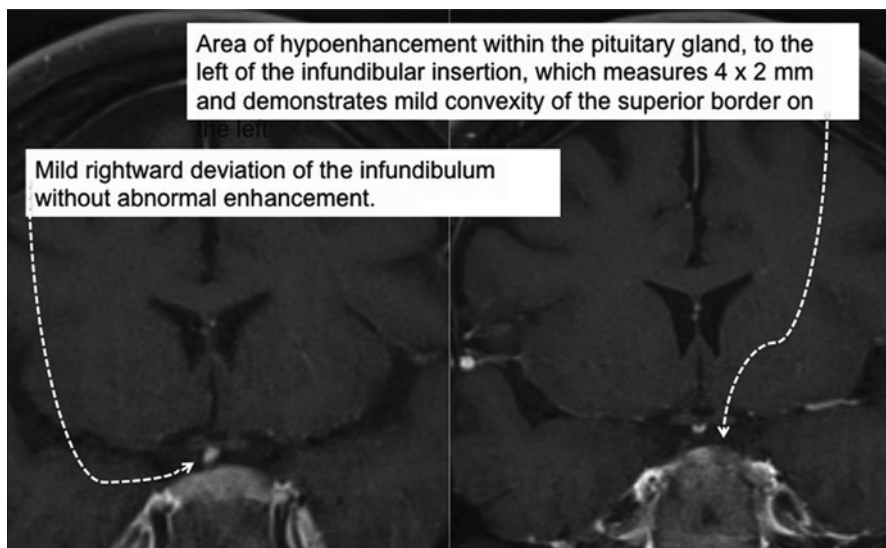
Pituitary MRI findings in a 24-year-old woman with CS
